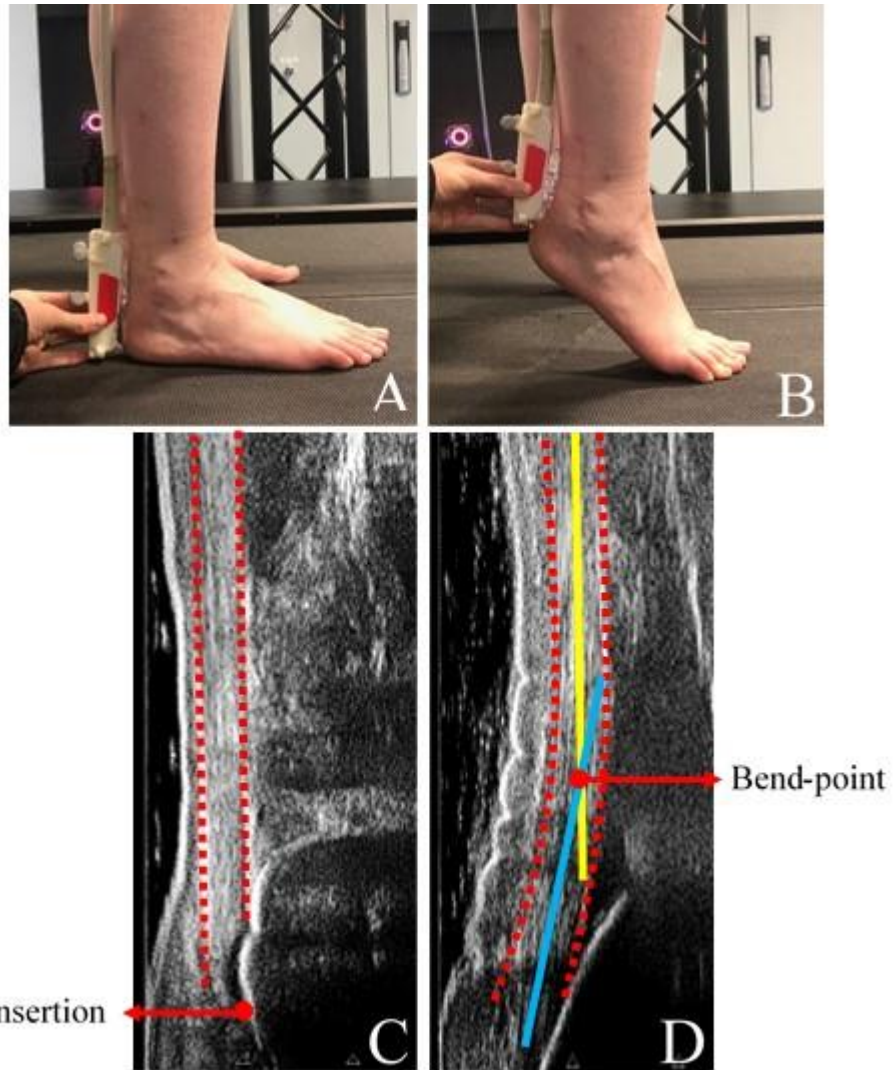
(A) Experimental set-up, showing ultrasonography positioned in the sagittal plane to identify Achilles tendon insertion and (B) Achilles tendon bend-point. (C) Identification of Achilles tendon insertion from ultrasound images taken during standing. (D) Identification of Achilles tendon bend-point from ultrasound images taken during loaded plantarflexion. Dashed red: Outline of Achilles tendon path, solid yellow: straight portion of Achilles tendon, solid blue: initial path of Achilles tendon. Bend-point was defined as the intersection of the yellow and blue lines. During data collection, the bend-point was judged visually.
